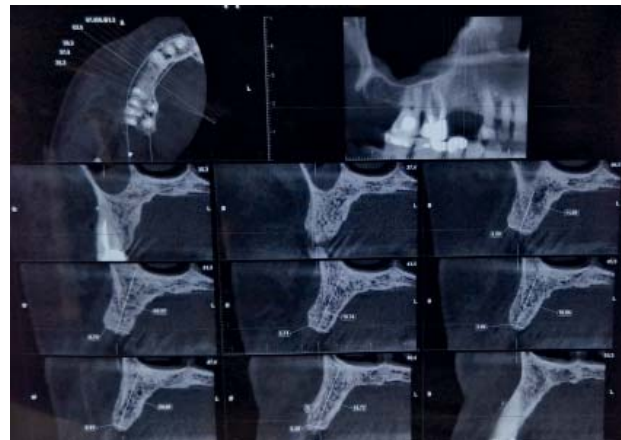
B Preoperative alveolar bone deficiency – CBCT
